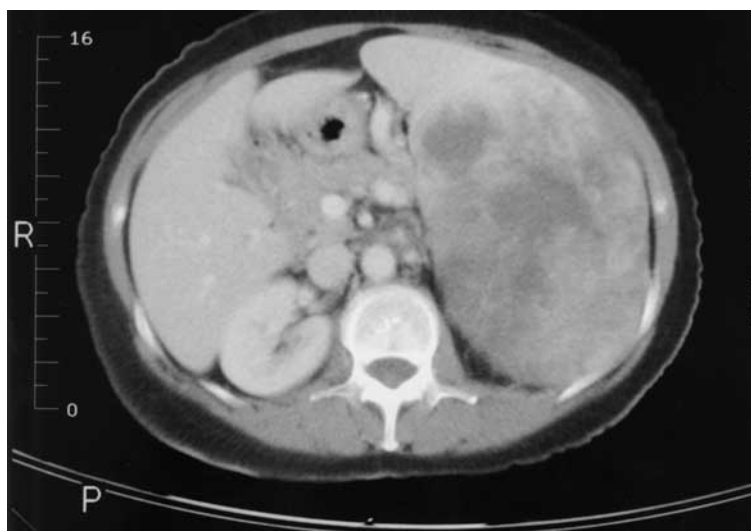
Contrast-enhanced CT of the abdomen showing large necrotic tumor of the spleen.
